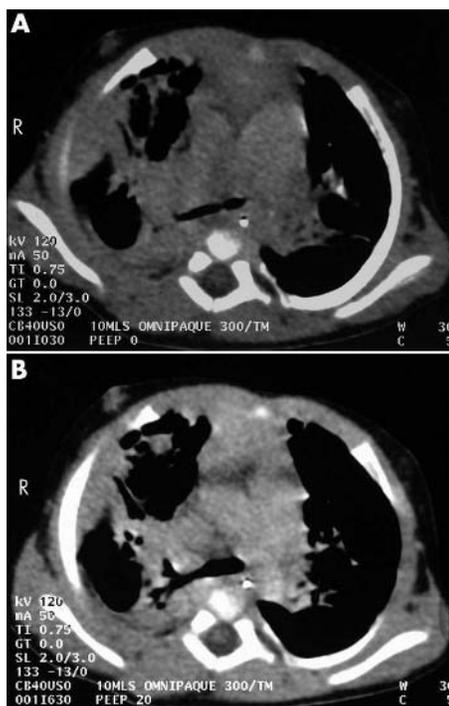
Computed tomography of the same patient as in fig 1 showing bronchomalacia at (A) positive end expiratory pressure (PEEP) of 0, which was overcome by (B) PEEP of 20 cm H₂O.
